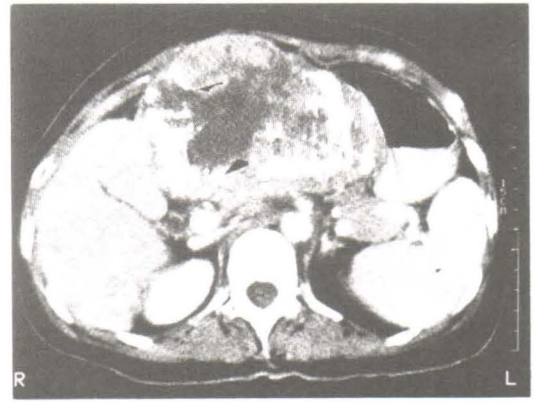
Lipiodol CT scan post repeated TOCE of hepatic artery shows nonopacified portion by lipiodol at right and left liver lobes at anterosuperior portion adjacent to diaphragm representing residual HCC (arrow).
